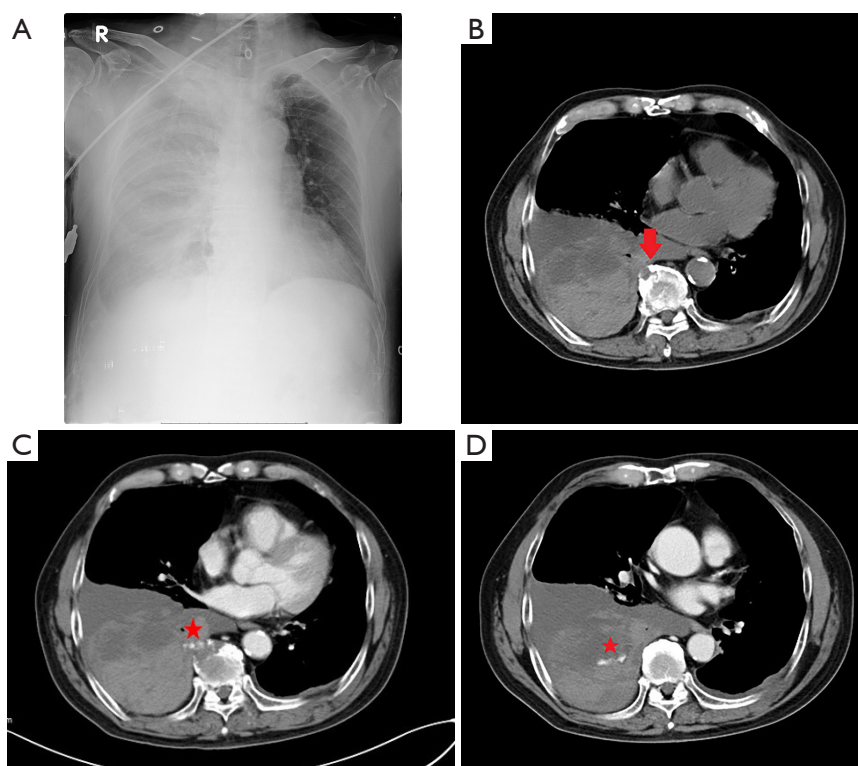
Image of a patient diagnosed with intercostal artery injury. (A) Chest X-ray showed a massive right pleural effusion. (B) Non-contrast CT revealed a fracture of the anterior-superior endplate of thoracic spine No. 9 body (arrow). (C,D) Contrast enhanced computed tomography (CT) manifested contrast extravasation at the right intercostal artery (star) resulted from the fractured thoracic bone fragment, which caused the right hemothorax.
